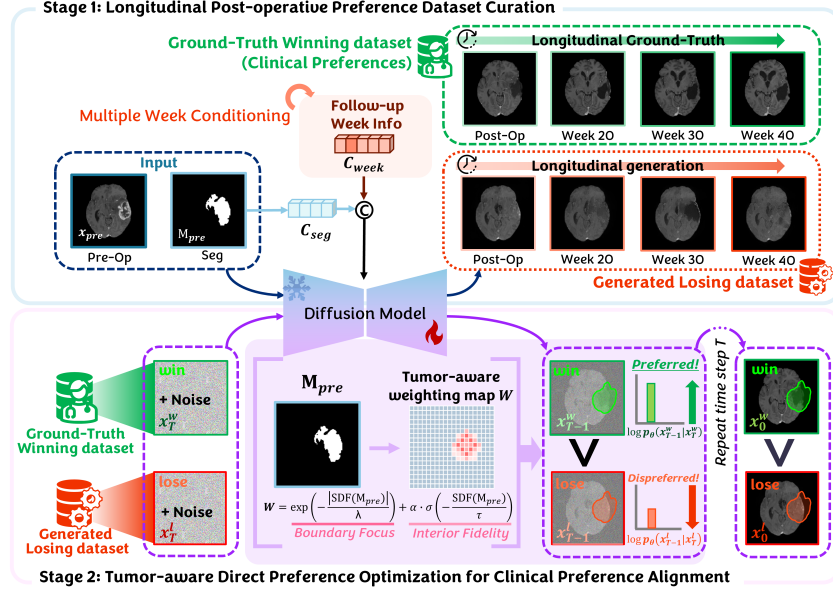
TADPO for longitudinal post-operative MRI generation consists of (Stage 1) preference dataset curation by pairing ground-truth (“winning”) and generated (“losing”) MRIs and (Stage 2) tumor-aware DPO focused on key tumor progression regions.
